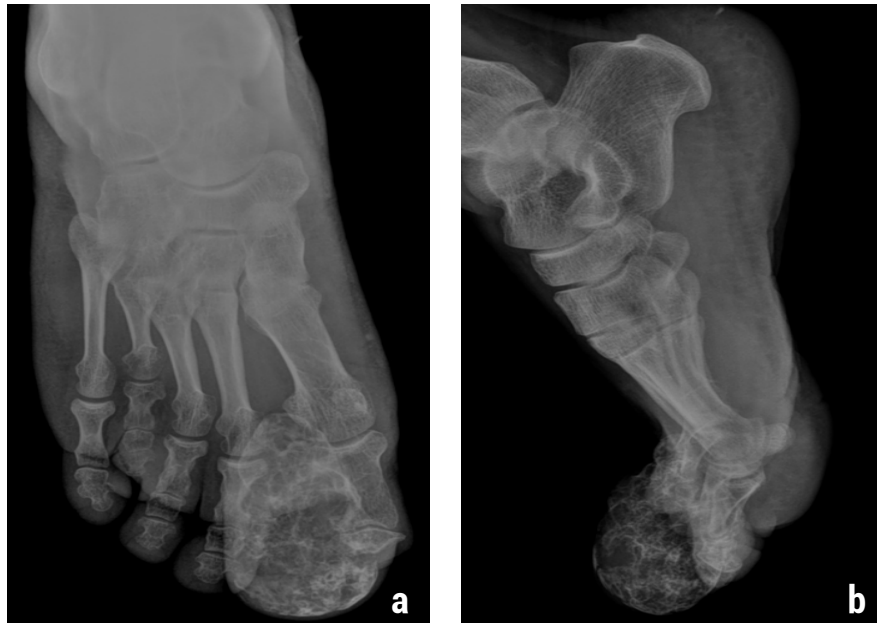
a) Antero-posterior X-ray of the right foot. b) Lateral X-ray of the right foot.
